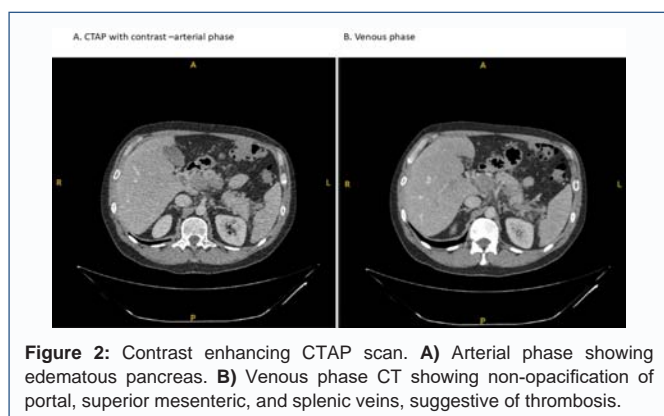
Contrast enhancing CTAP scan. A) Arterial phase showing edematous pancreas. B) Venous phase CT showing non-opacification of portal, superior mesenteric, and splenic veins, suggestive of thrombosis.
